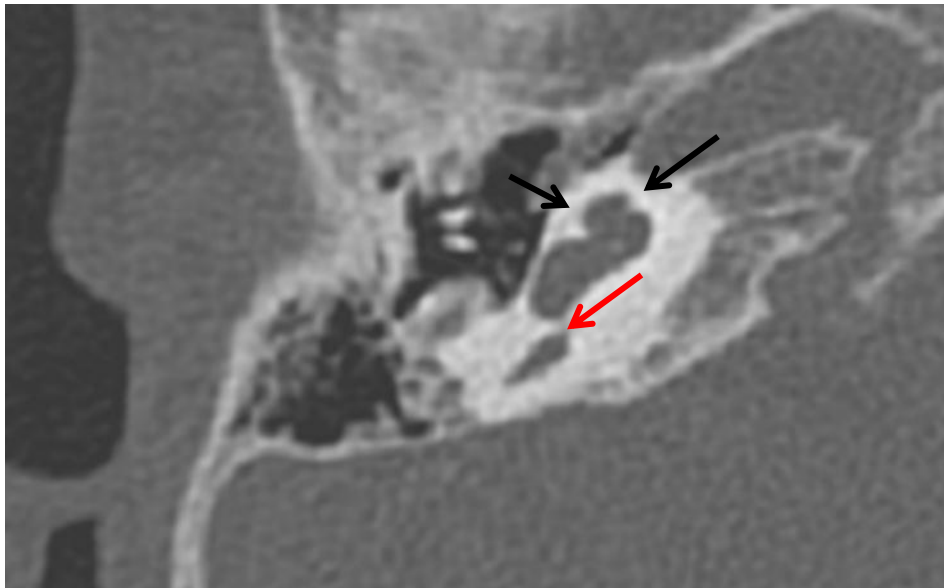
CT and MRI temporal bone. Hypoplastic cochleae and dilated saccules.
